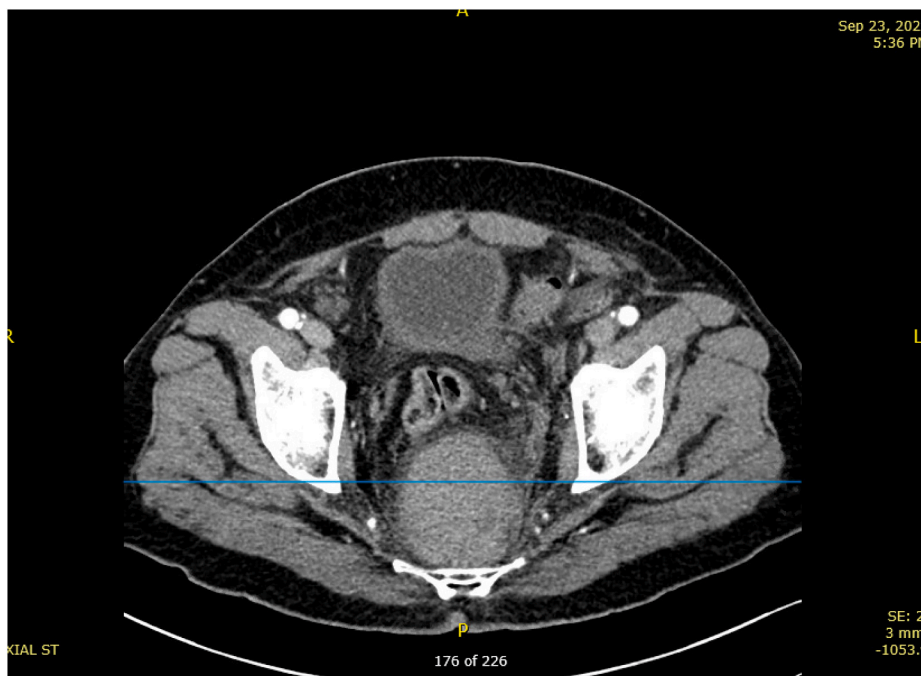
Axial CT view demonstrating the retroperitoneal hematoma displacing the rectum and the anal canal anteriorly.
